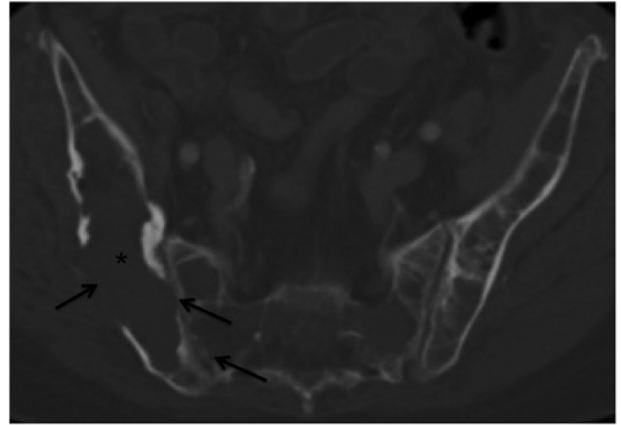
(Patient 2) Axial computed tomography image through the pelvis shows the upper portion of the right iliac deforming mass cavity (*) with lateral cortical destruction and multiple areas of medial near-complete cortical loss along the sacro-iliac joint in the ilium more than the sacral wing (arrows). A smaller right anterior sacral wing lytic cavity is also present.
